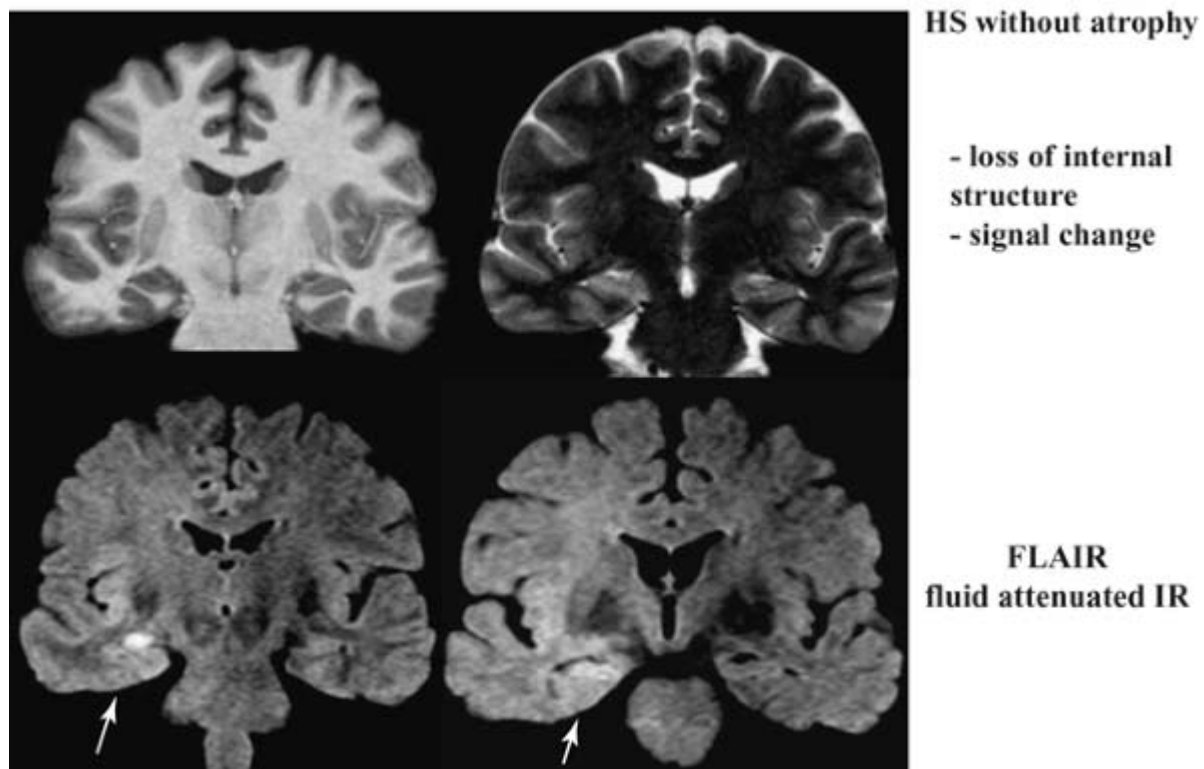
Atrophy of the hippocampus is not apparent in this case of hippocampal sclerosis (HS). There is signal change in the hippocampus that may be considered to be subtle. When assessed with fluid-attenuated inversion recovery (FLAIR) imaging, the signal change is dramatic, and there is a suggestion of changed signal more extensively throughout the hemisphere. The latter subtle change should be interpreted with care because FLAIR imaging can give a variety of artifacts. In this case this was confirmed on T2 relaxometry studies. (See also Fig. 18.)
